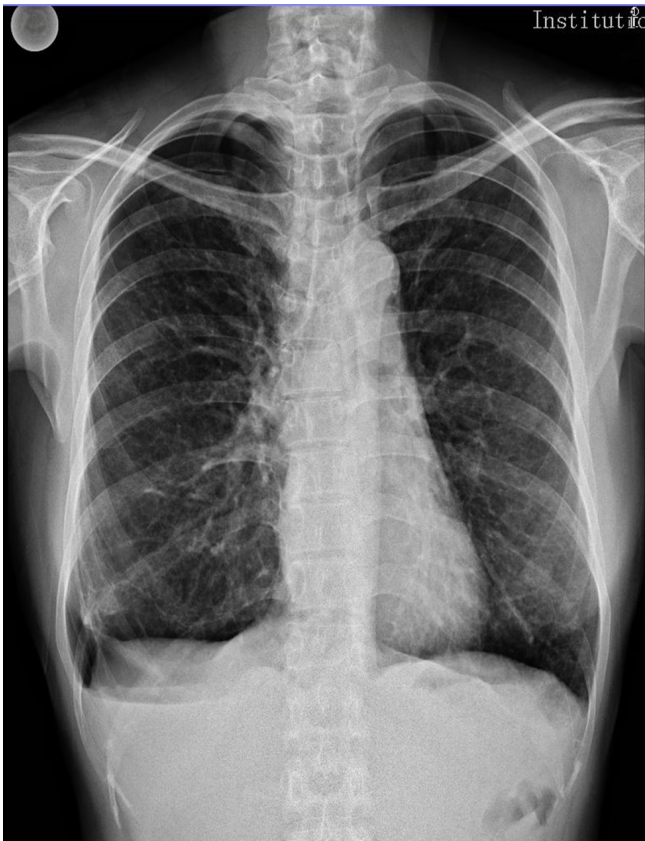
Chest x-ray showing minimal pneumothorax in the right apex
